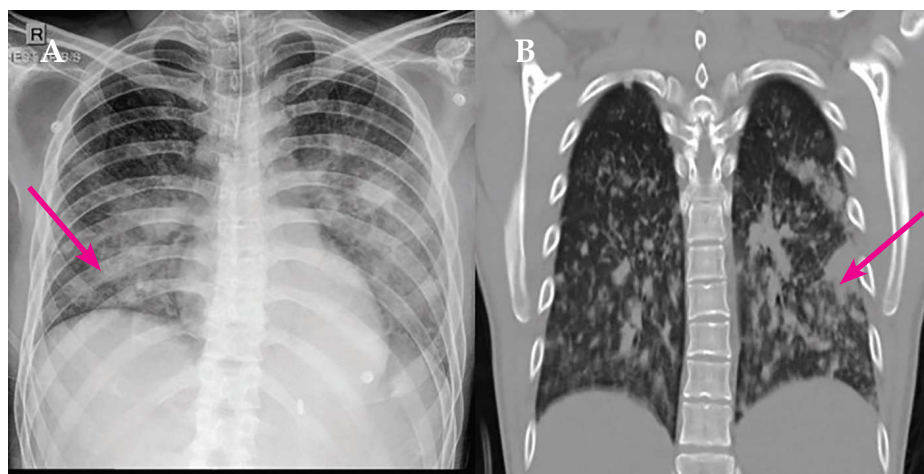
(A) Chest X-Ray showed multiple radio opacities in bilateral lung fields, (B) CT chest showed Patchy subpleural consolidations with nodules in bilateral lungs
